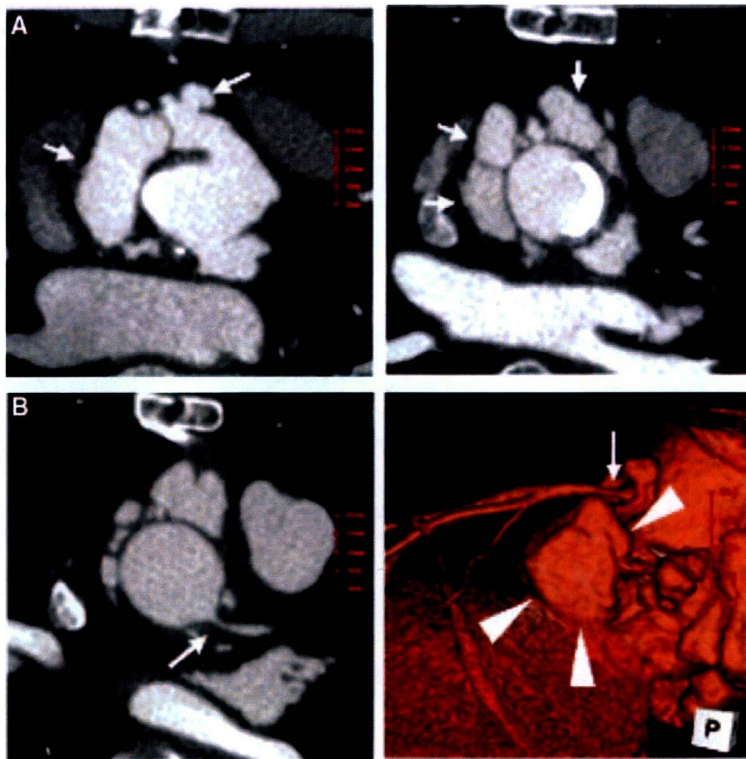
A, Multislice computed tomography reveals the development of multiple pseudoaneurysms around the aortic graft (arrows). B, One of those pseudoaneurysms oppresses the left main trunk (triangle) and causes severe stenosis (arrows).
